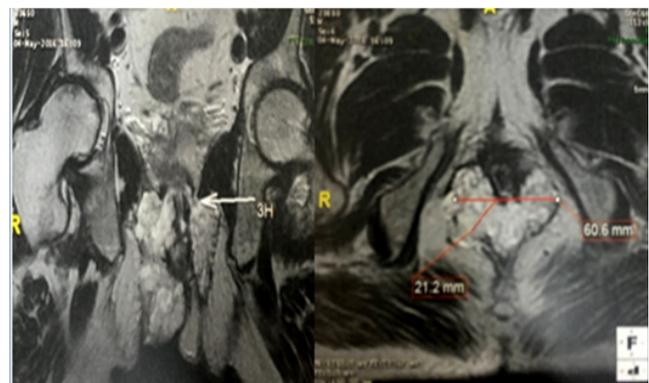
Pelvic MRI: trans-sphincteric complex fistula with 4 primary orifices associated with a perianal abscess measuring 4 cm extended to the 2 ischioanal fossae.
